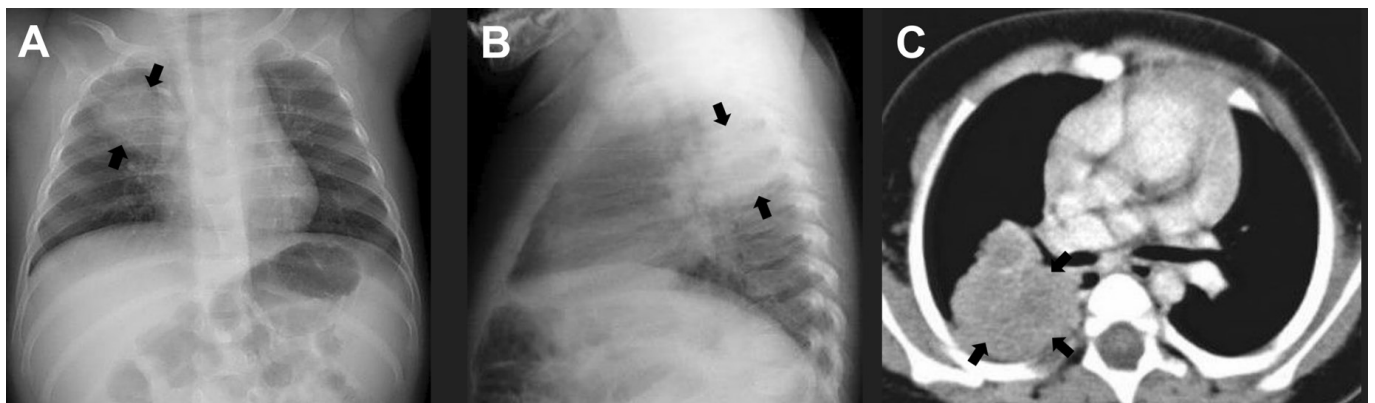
A 10-month-old boy with fever and cough. Posterioranterior (A) and lateral (B) chest radiographs with chest CT (mediastinal window) (C) show a well-defined round pneumonia (arrows) in the right upper lobe posterior segment.
